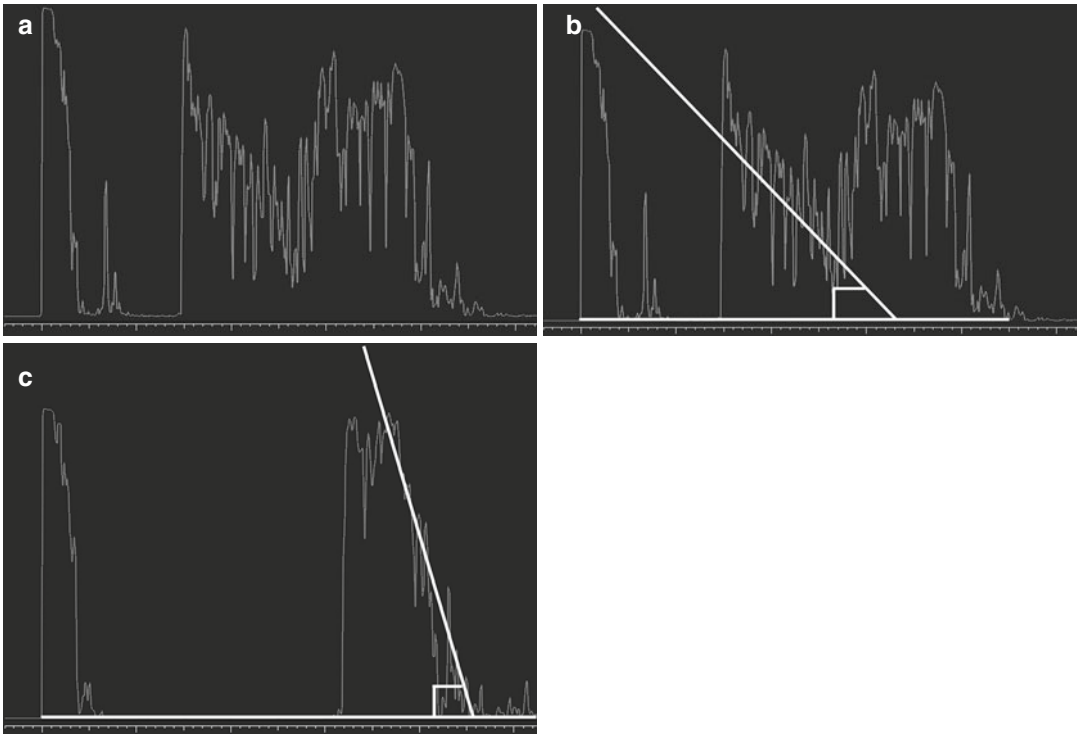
Quantitative ultrasonography (sound attenuation, A-scan, angle Kappa). Progressive decrease in the height of the spikes can be depicted as an angular measurement (a, b). Angle kappa is proportional to the extent
